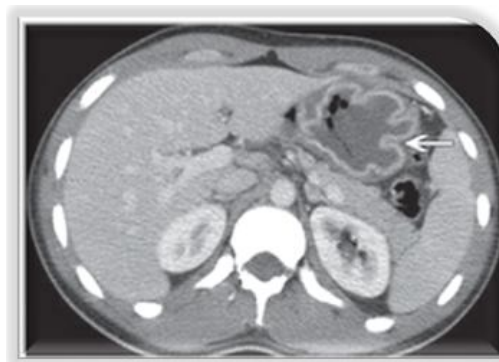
Axial contrast material-enhanced CT image at the level of the gastric fundus shows gastric wall thickening and enhancement (arrow)Source: Radiographics (2009).
